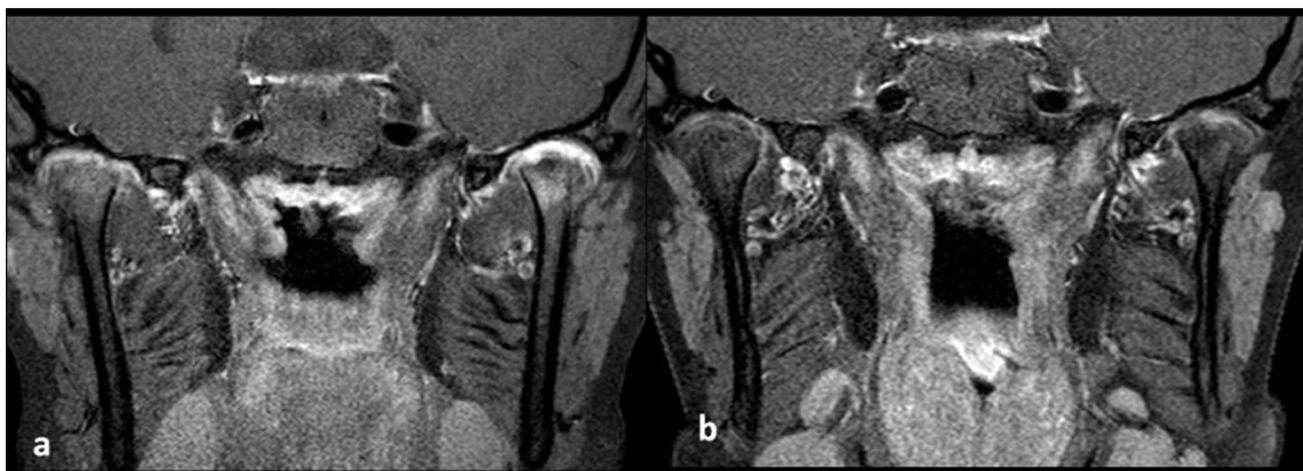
Patient 10: coronal postcontrast fat-saturated T1-weighted MR images show flattening of both mandibular condyles with irregular outline and erosions (a, b). Compared to previous MRI (a), there was
